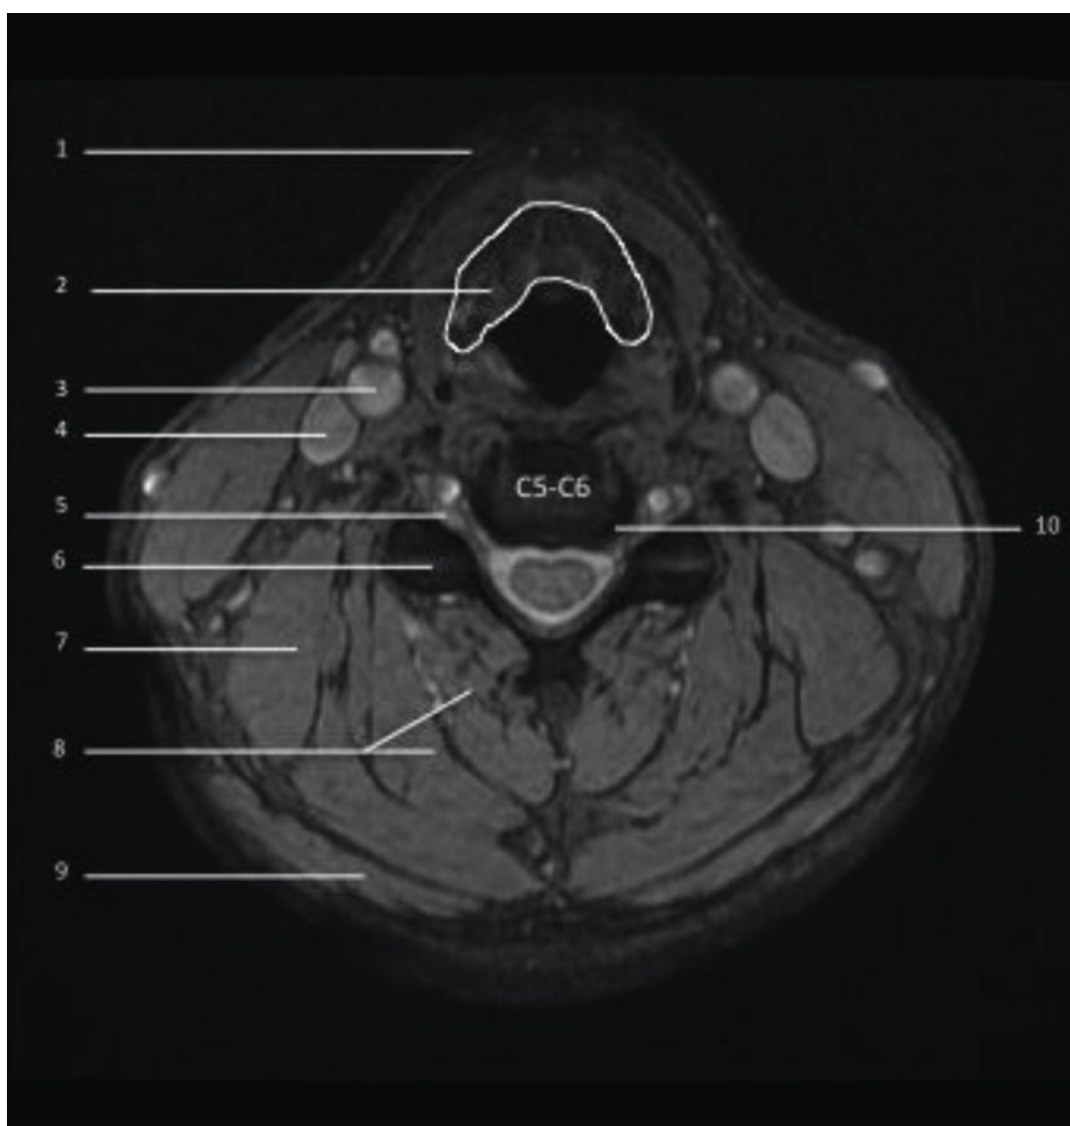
Magnetic resonance imaging, axial cut at C5–C6. 1, platysma muscle; 2, thyroid gland; 3, common carotid artery; 4, internal jugular vein; 5, normal exiting nerve root; 6, facet joint; 7, longus colli muscle; 8, deep cervical muscles; 9, trapezius; 10, left herniated nucleus pulposus (HNP) causing foraminal stenosis.
